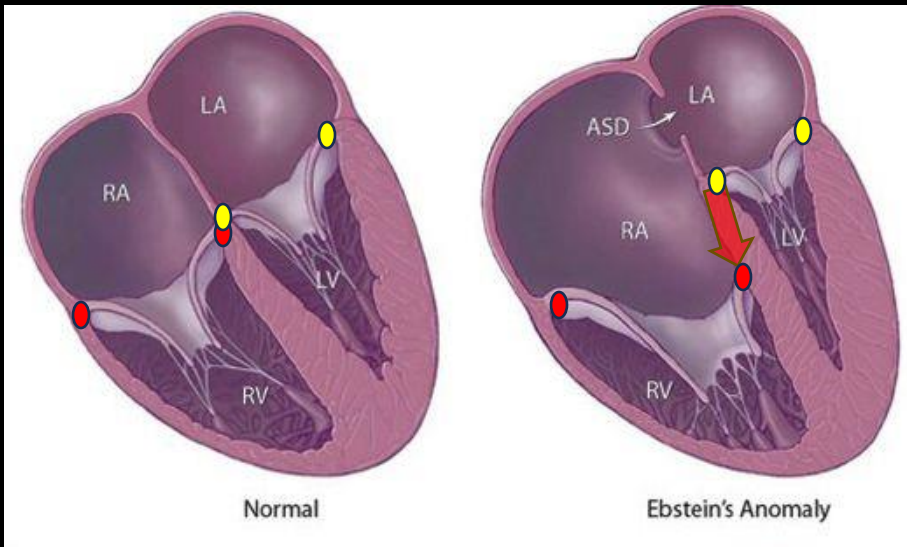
Image source: Echocardiography in Pediatric and Congenital Heart Disease: From Fetus to Adult
